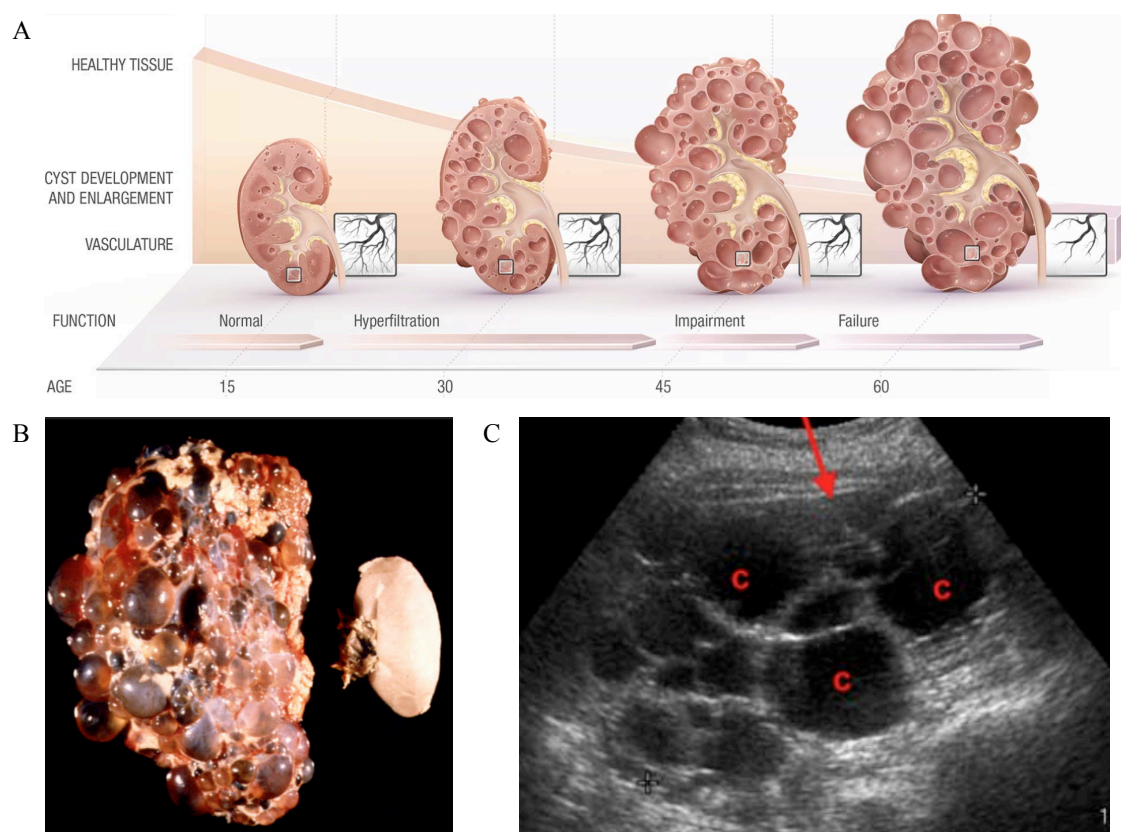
A) Cysts formation and development in an age dependent manner. The cysts development causes the progressive renal failure (PKD foundations 2017); B) ADPKD kidney compared with normal kidney (University of Virginia 2015); C) ADPKD patient renal ultrasound. The dark areas labeled with "C" represent cysts. Several smaller cysts are can also be seen (University of Virginia 2015).
